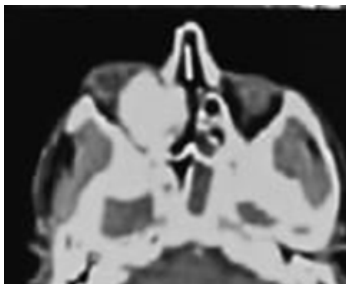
Axial CT Image showing osteoma encroaching the orbit
